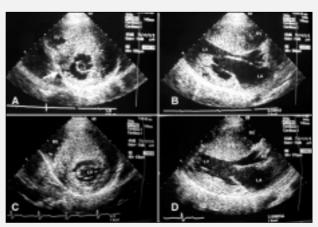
$1 \cdot A$ and B) two-dimensional echocardiogram of twin V; C and D) two-dimensional echocardiogram of twin G. In A and C (short axis), the LV hypertrophy is more diffuse in twin G. Note a displasy in the inferior wall of twin V (arrow). In B and D (long axis), similar IVS thicknesses are showed but the PW is more hypertrophied in twin G. RV- right ventricle cavity; LA- left atrium; AO- aorta; LV-left ventricle cavity; IVS- interventricular septum; PW- posterior wall.
